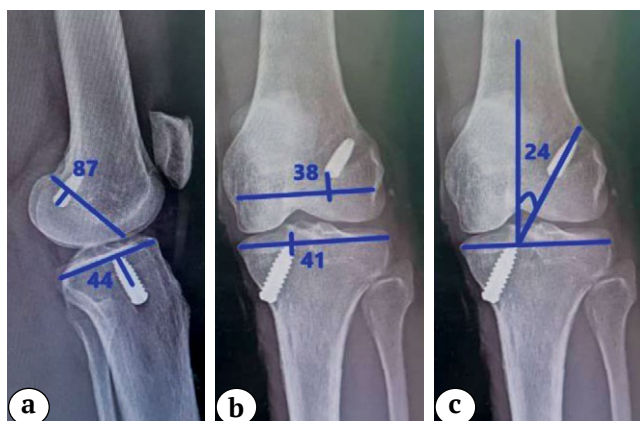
A patient’s postoperative X-rays showing anatomical tunnel parameters and GIA:
